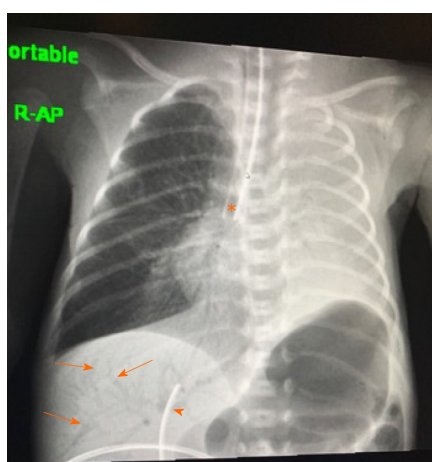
Abdominal radiograph showing portal gas (arrows) due to malposition of umbilical catheter (arrow head), and an incidental finding of right main bronchus intubation (asterisk) causing left sided atelectasis.
